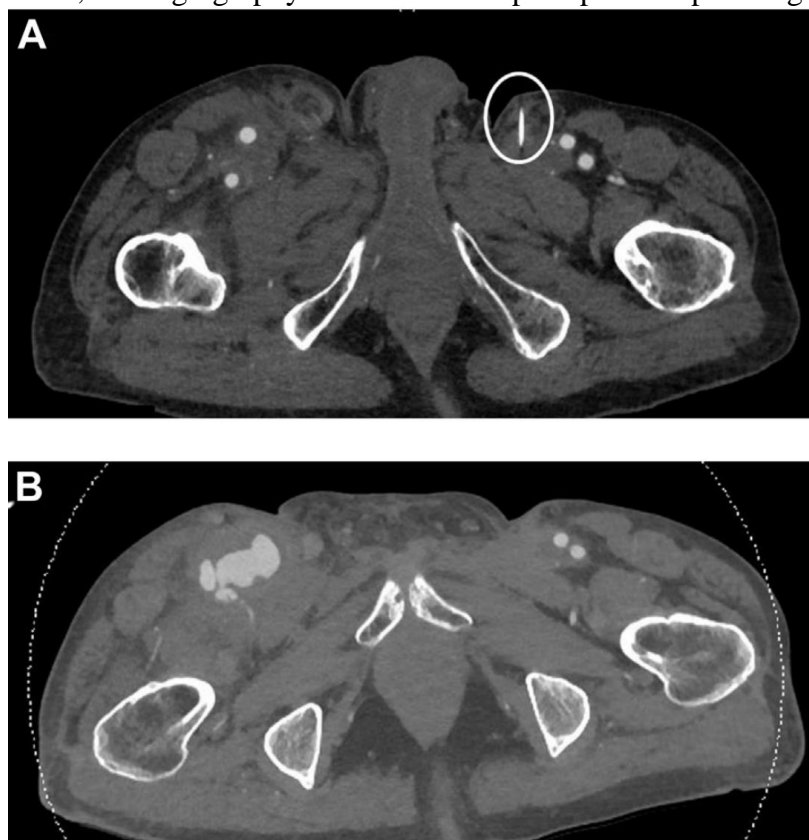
computed tomographic arteriogram showing A, Retained needle fragment in left groin subcutaneous tissue (white circle). B, Large femoral pseudoaneurysm (PSA) at the level of the right femoral bifurcation (8).
